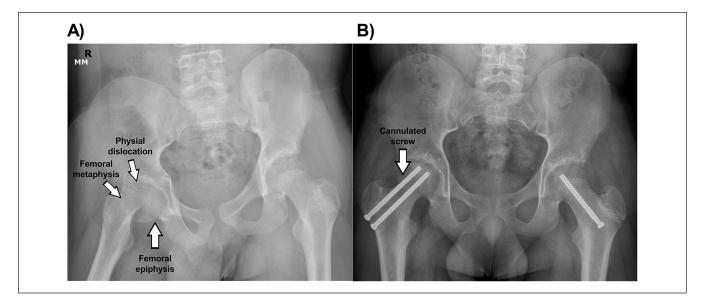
(A) Anteroposterior radiograph of severe slipped capital femoral epiphysis with near-complete physeal dislocation. Note the posteroinferior displacement of the femoral epiphysis from the metaphysis through the physis (growth plate). (B) Anteroposterior radiograph after an open reduction and percutaneous pinning of the right hip and prophylactic closed reduction percutaneous pinning of the left hip. Cannulated screws are highlighted through the femoral metaphysis, physis, and epiphysis to correct the deformity and prevent further slippage.
